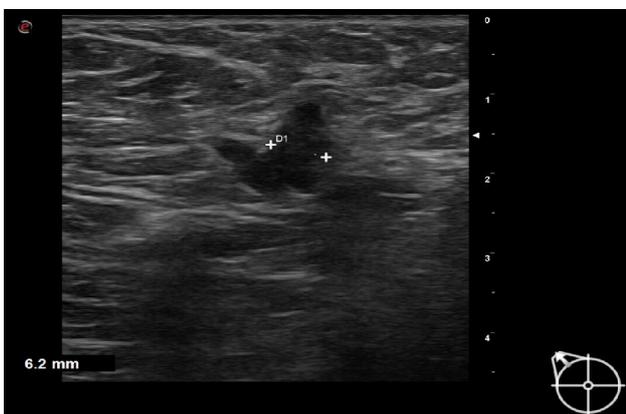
Axillary ultrasound. Image of the right axillary adenopathy.
